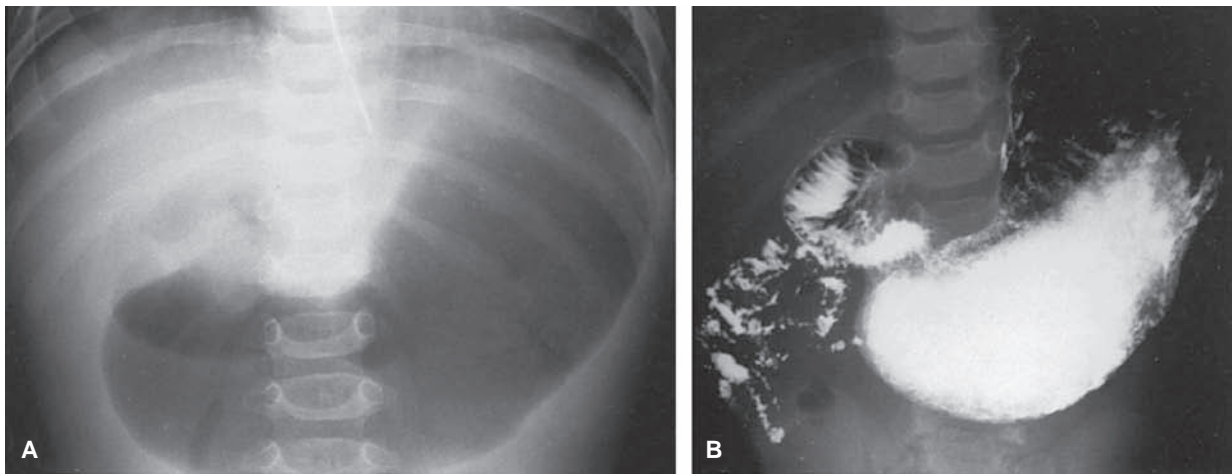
A: Malrotation of the bowel. Supine plain roentgenogram of the abdomen shows distended stomach and proximal duodenal loop. B: Same patient as in A. Upper gastrointestinal series shows dilated proximal duodenum with abrupt transition to normal caliber of small bowel. Abnormally placed ligament of Treitz. Proximal jejunum in the right abdomen.
